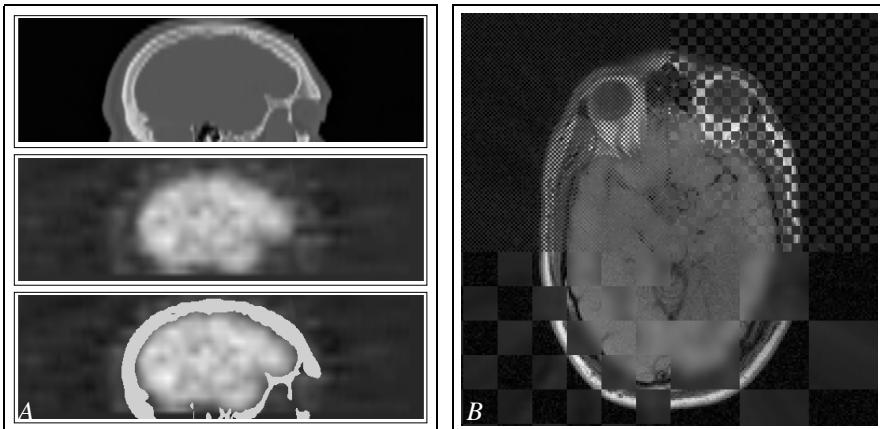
Examples of integrated 2D displays of registrations based on Mutual Information. Frame (A): Adjacent display of a CT image (top), PET image (middle), and PET image with superimposed skull from the CT image (bottom). Frame (B): 'Checkerboard' display of a PET and MR image where the four quadrants have different checkers size (top left: 1 pixel (= alternate pixel display), top right: 4 pixels, bottom left: 16 pixels, and bottom right: 32 pixels).
